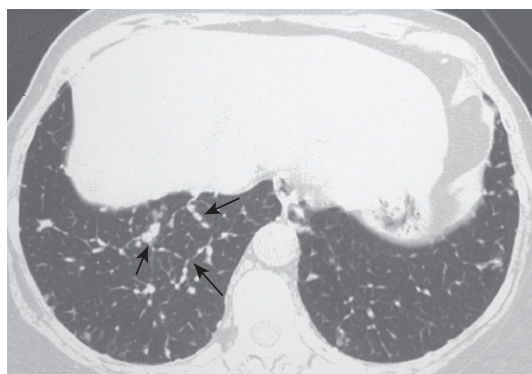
HRCT scan of the chest showing nodular interlobular septal thickening at the lung bases, particularly at the right lung base (arrows).
